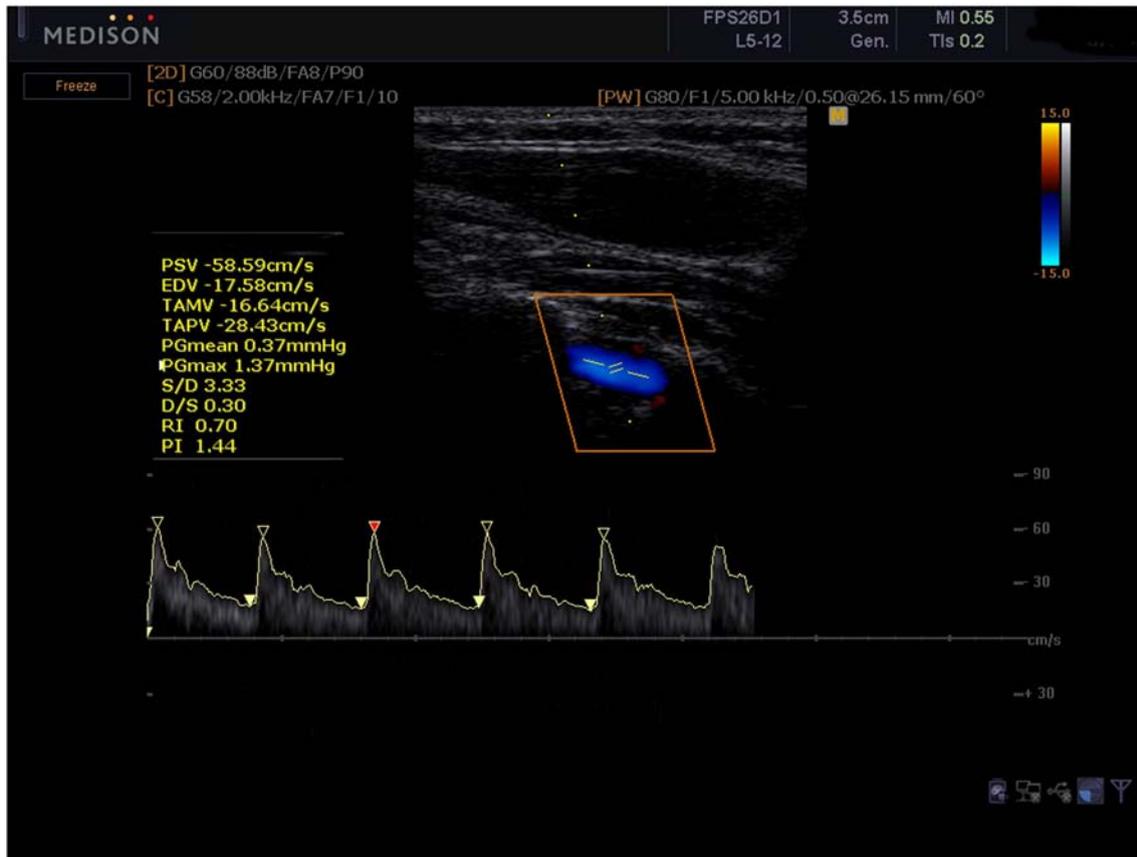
Doppler ultrasound imaging measured at the lower cervical spine between fifth cervical vertebra and sixth cervical vertebra. Color version of figure available online.
